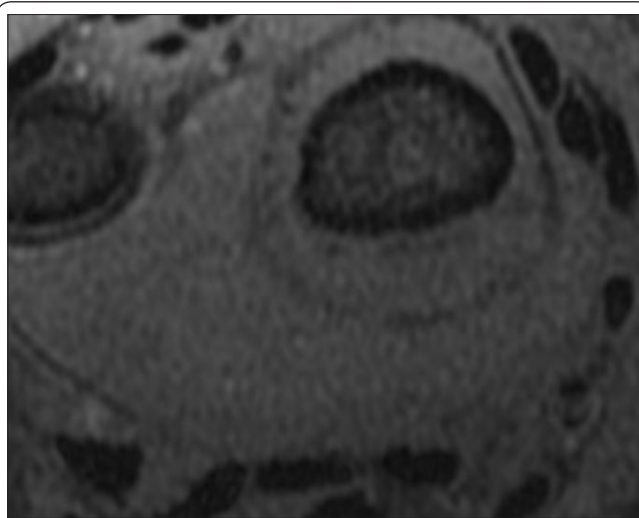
T1 weighted non-contrast MRI of the right wrist showed a soft tissue mass of the distal radial metaphysis.
